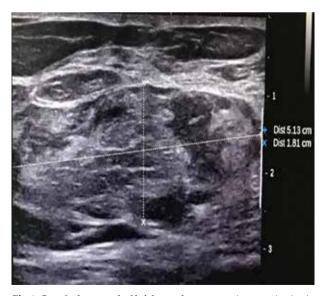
Case 3 ultrasound of left breast hamartoma increase in size in 6/12
